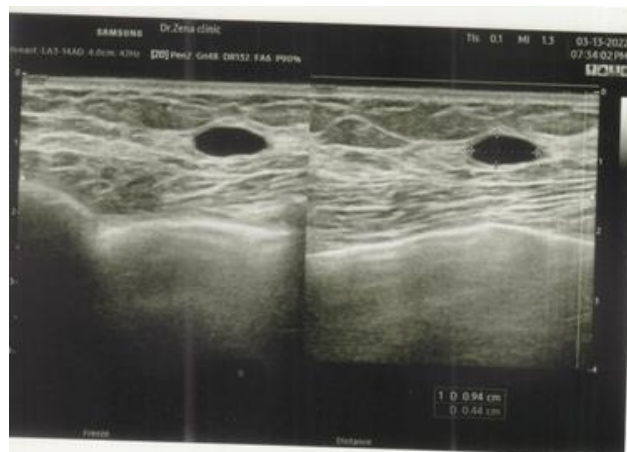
Ultrasound Image of 29 Years Old Female Show Simple Cyst in Right Breast Measure 9.4 x 4.4mm.
